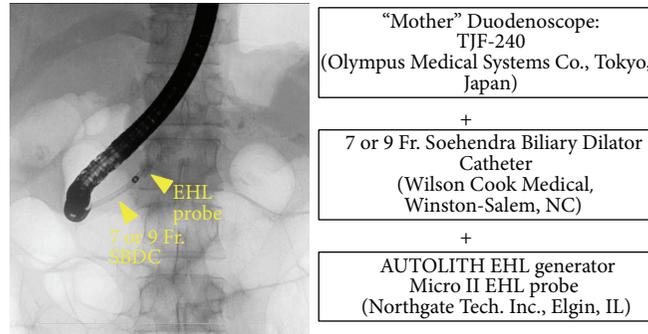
X-ray guided EHL.
